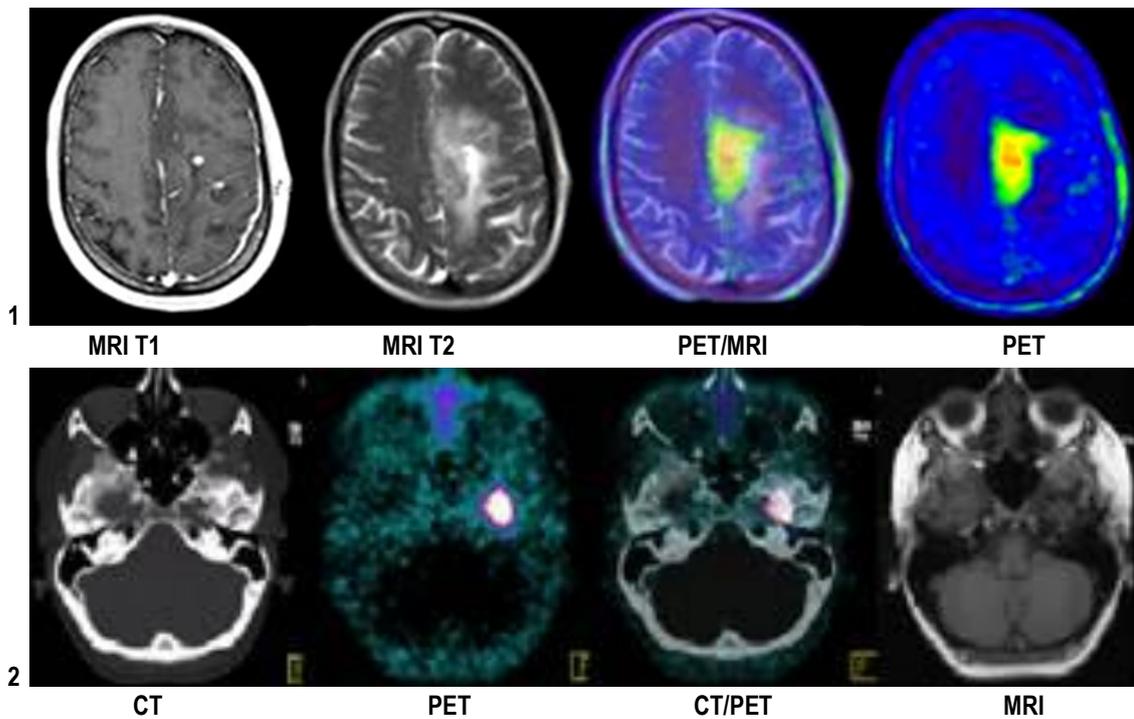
The results of tumor detection on CT/PET/MRI-scans (<http://www.vivantes.de>)
